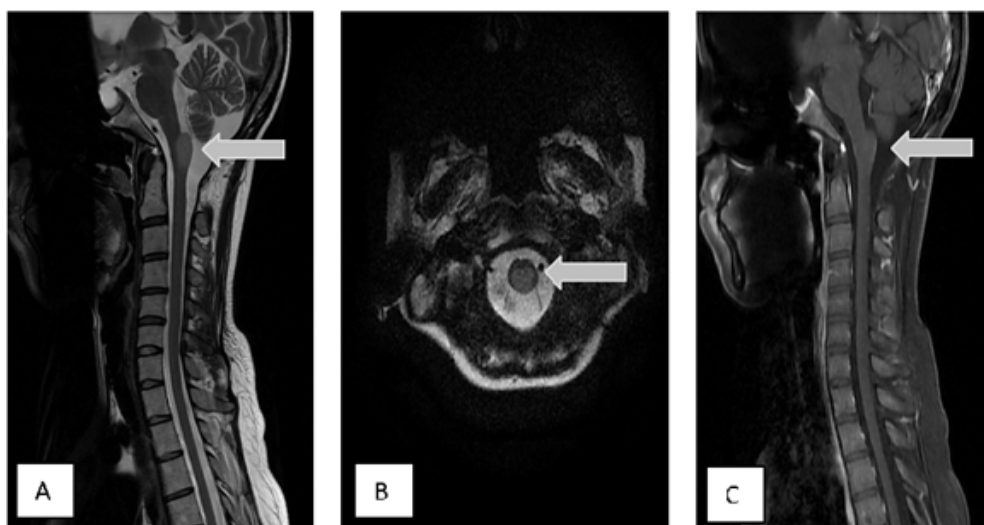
A. Sagittal-T2WI, B. Axial T2WI and C. Sagittal T1WI post contrast MRI images showed intra-axial lesion at the level of medullary cervical junction (arrow). It is high signal intensity on T2WI (A & B) and showed faint enhancement (C) in keeping with a metastatic lesion.
